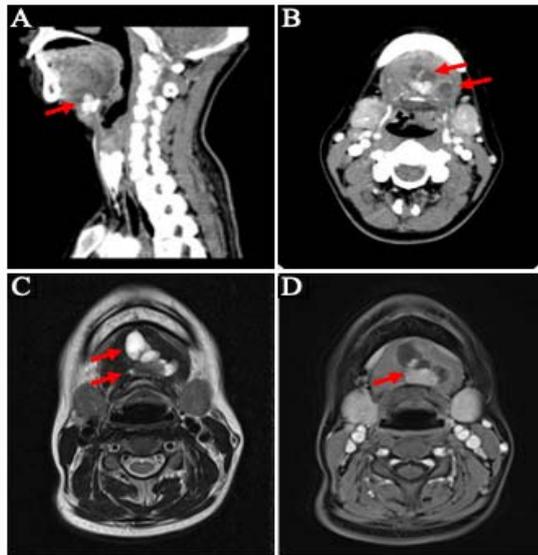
Computed Tomography (CT) and magnetic resonance imaging of the mass. a 4 cm × 2 cm diameter multilocular, midline, thyroglossal duct cyst was confirmed (red arrow), with obviously strengthened solid components and burrs on the edges after enhancement. A and B showed CT scan; C and D represented MR scan.
